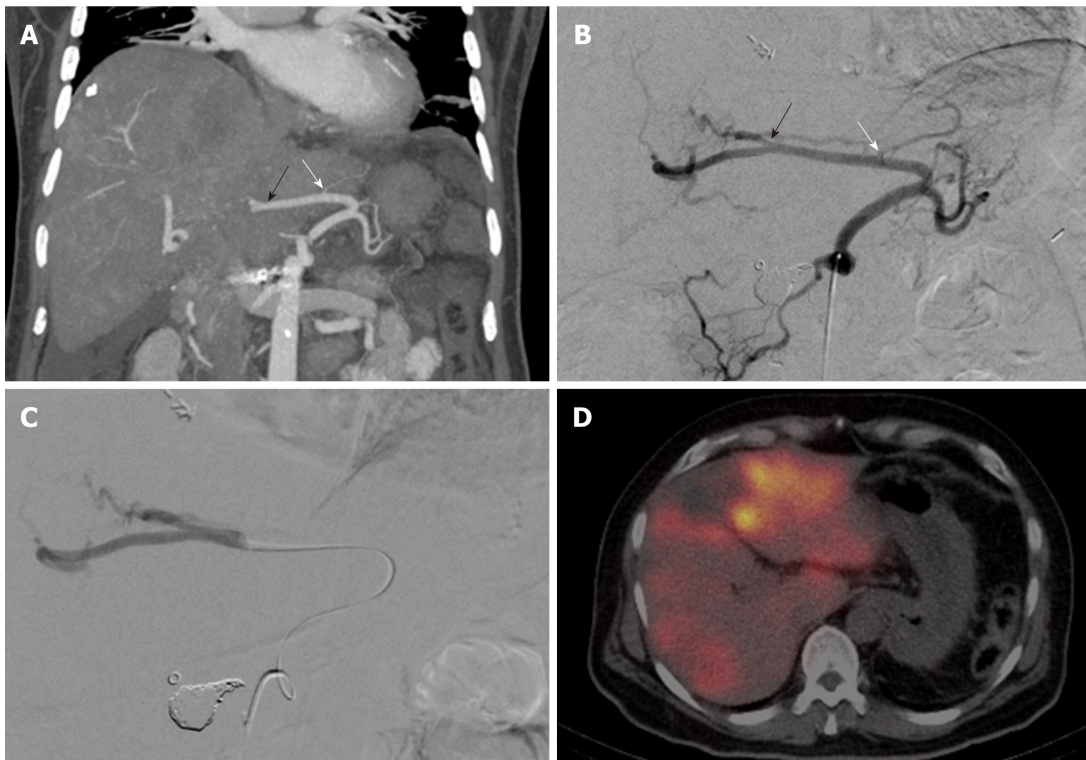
Sample case. 52-year-old patient with an aberrant left hepatic artery originating from the left gastric artery and multifocal colorectal liver metastases in both hepatic lobes. A: Preinterventional computed tomography (CT) angiogram (coronal maximum intensity projection) displaying the distance between the most distal hepatoenteric side branch (white arrow) and the first intrahepatic branch of the aberrant left hepatic artery (LHA) (black arrow); B: Vascular anatomy on the preliminary mapping angiogram. (white arrow: most distal hepatoenteric side branch; black arrow: first intrahepatic branch of the aberrant LHA); C: Catheter position during test injection of technetium ^{99m}Tc macro aggregated albumin (^{99m}Tc -MAA) (and subsequently also during delivery of the ^{90}Y microspheres); D: Post- ^{99m}Tc -MAA SPECT/CT showing good tumoral ^{99m}Tc -MAA uptake and no extrahepatic activity.
